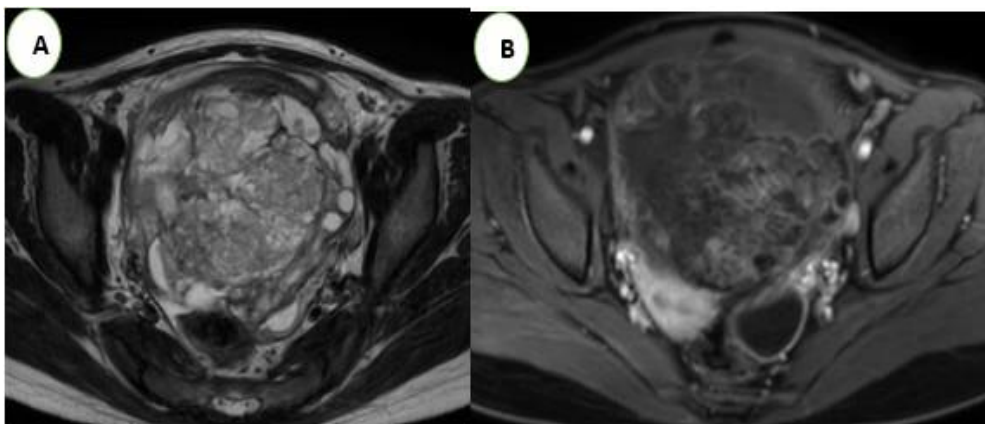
Pelvic MRI T2 axial sequences (A) and T1 FATSAT with gadolinium injection (B) of the same patient confirming the ovarian origin of the teratoma
